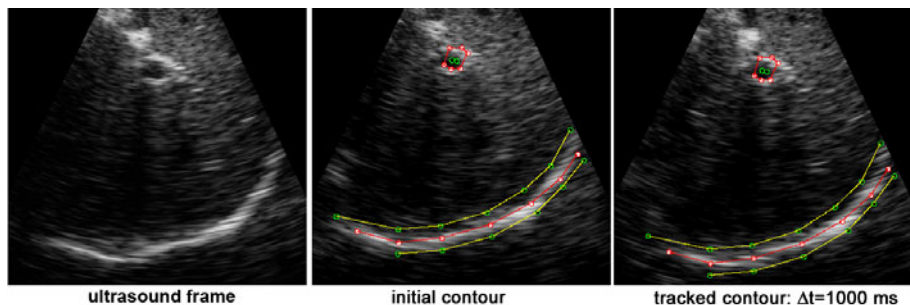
Left: The field of interest in a ultrasound frame. Middle: The initial contour(28 points) overlaid on the first frame($\Delta t=0$ ms) of the liver ultrasound data. Right: The tracking contour from our real-time algorithm overlaid on a later frame during deep breathing ($\Delta t=1000$ ms).
